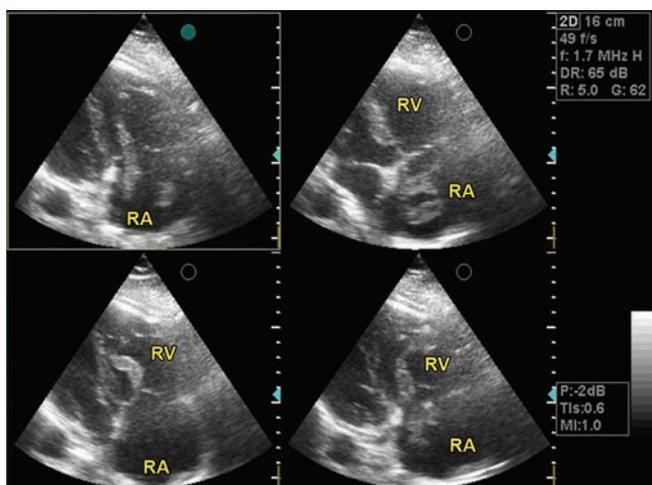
Transthoracic echocardiography (modified parasternal right ventricular inflow view) shows a mobile mass in the right atrium.
